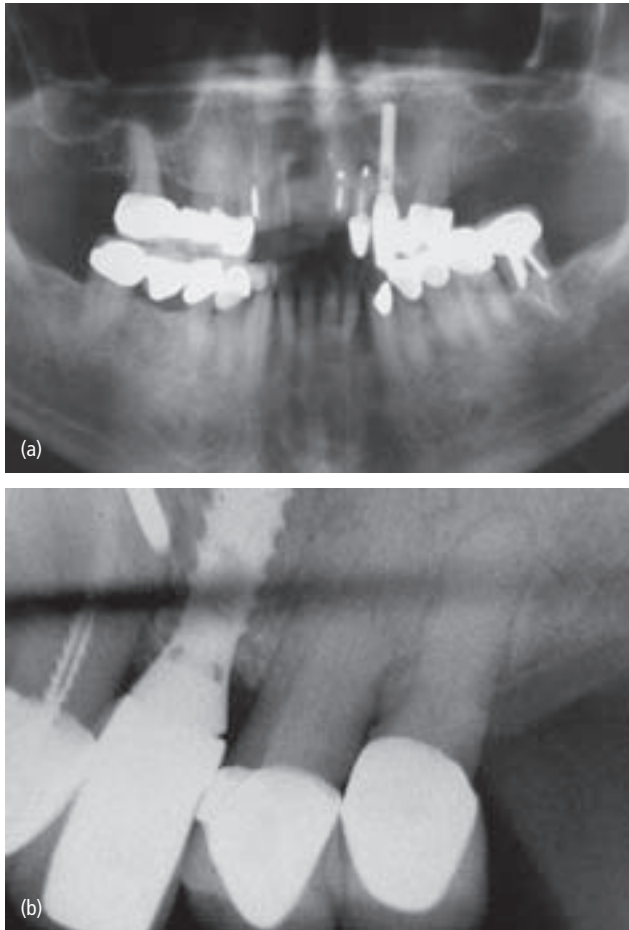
(a) Panoramic radiograph with limited diagnostic clarity of tooth 12; (b) periapical displays improved diagnostic clarity of tooth 12.
